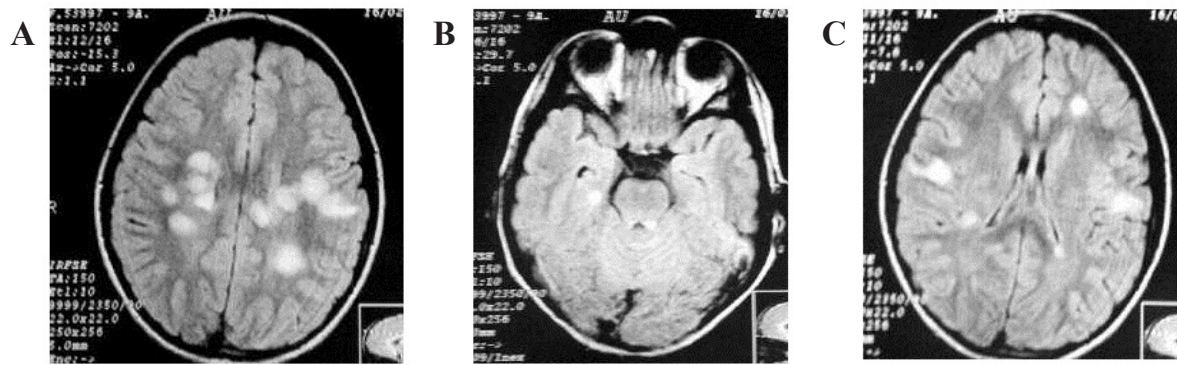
MRI showing multiple nodular, cotton-like images with hyperintense signal at T2 and in the long RT sequence and above all the flair sequence observed in the white matter of the semioval centers, as well as in the cortical regions of the left frontal lobe and suprasylvian regions, some of periventricular distribution in the corpus callosum. Hyperintense images were also observed in the right temporo mesial regions and in the left periaqueductal regions and in the path of the posterior legs of the internal capsules, the left middle cerebellar peduncle and the dentate nuclei of the cerebellum.
